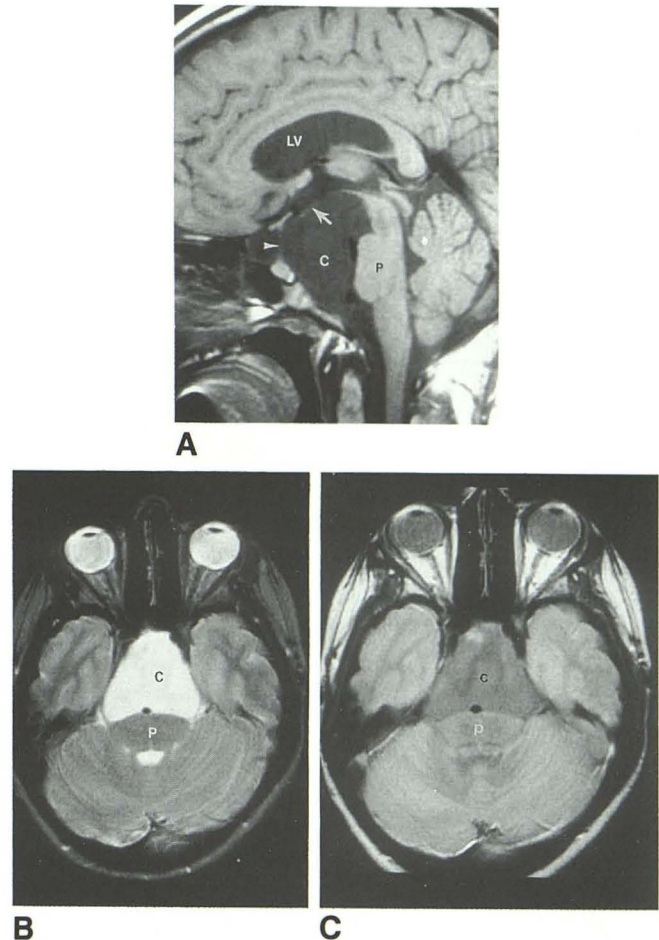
Sagittal T1-weighted (600/20) (A) and axial T2-weighted (2500/90) (B) and proton density (2500/30) (C) 1.5-T MR scans through the brain stem demonstrate a large retroclival arachnoid cyst (C) which is isointense with CSF on all imaging sequences. The cyst posteriorly displaces and flattens the brain stem (P = pons) and extends into the suprasellar cistern where it elevates the tuber cinereum (arrow) stretching the pituitary stalk (arrowhead). Enlargement of the lateral ventricles (LV) consistent with obstructive hydrocephalus is also seen.
